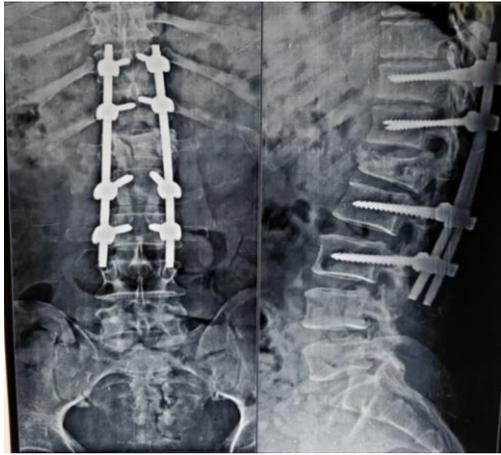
12 month post op X-ray.
